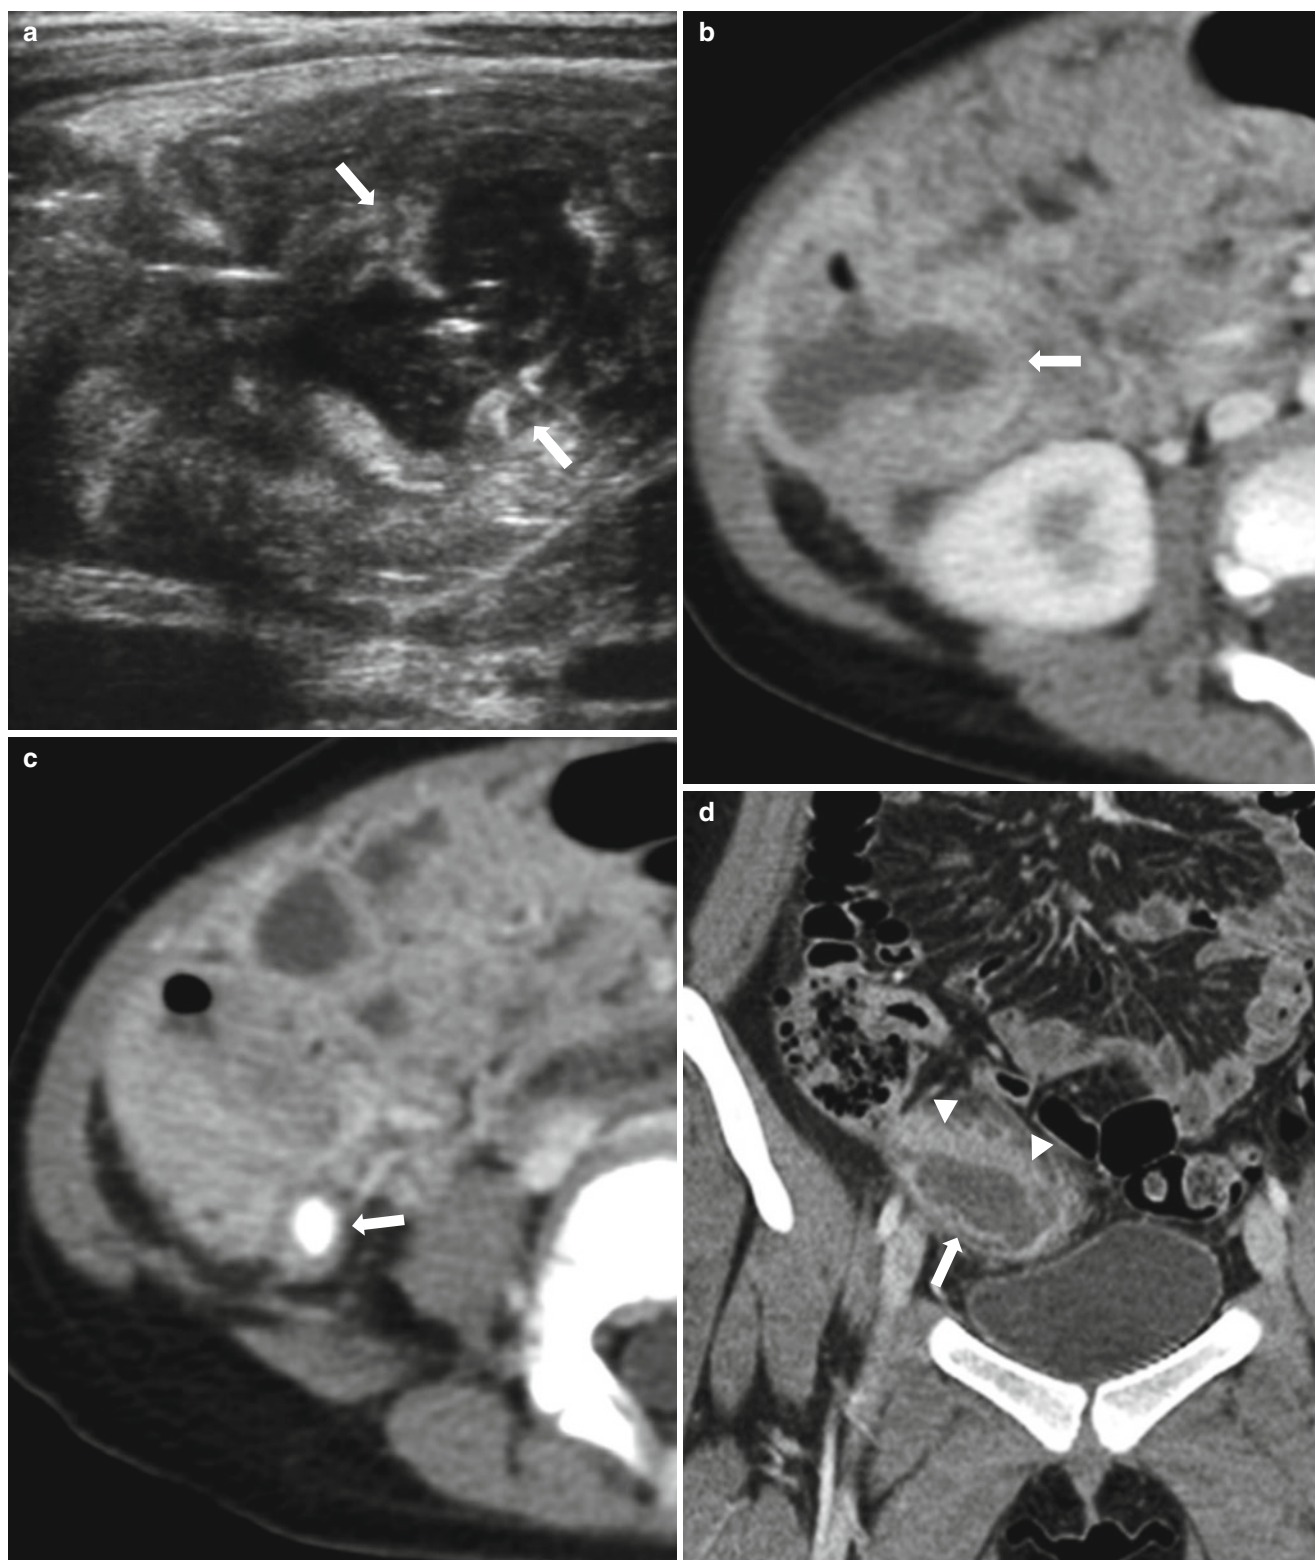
Periappendiceal abscesses in two children. (a–c) In this 2-year-old girl, initially performed US (a) shows a cavitory lesion (arrow) surrounded by a thick wall in the right subhepatic area, suspecting abscess. Appendix was not definitely identified on US. Contrast-enhanced CT images demonstrate an abscess (arrow in b) and an appendicolith (arrow in c) within the dilated appendix with a thick
